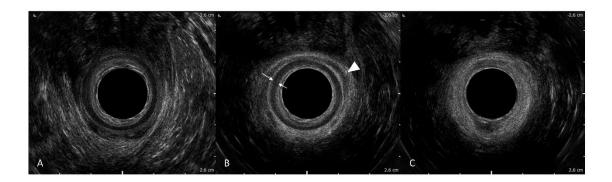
Representative normal endoanal ultrasound at high (A), mid (B), and (C) low levels. The IAS (white arrows) appears as a hypoechoic ring in high and mid-anal canal. The EAS (arrowhead) is shown as a hyperechoic ring surrounding the IAS. At low level (C) only the EAS is visible. The puborectalis sling is shown (C).
